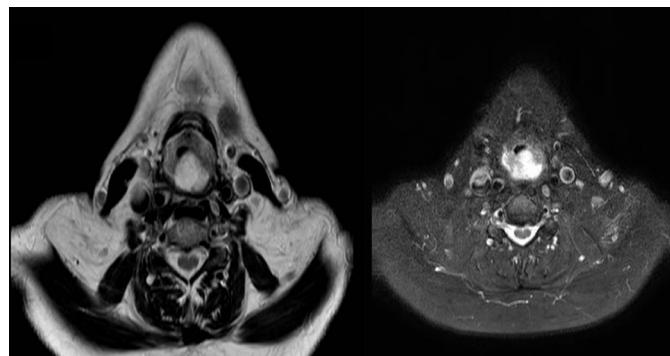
Gadolinium-enhanced magnetic resonance imaging of supraglottic hemangioma.
